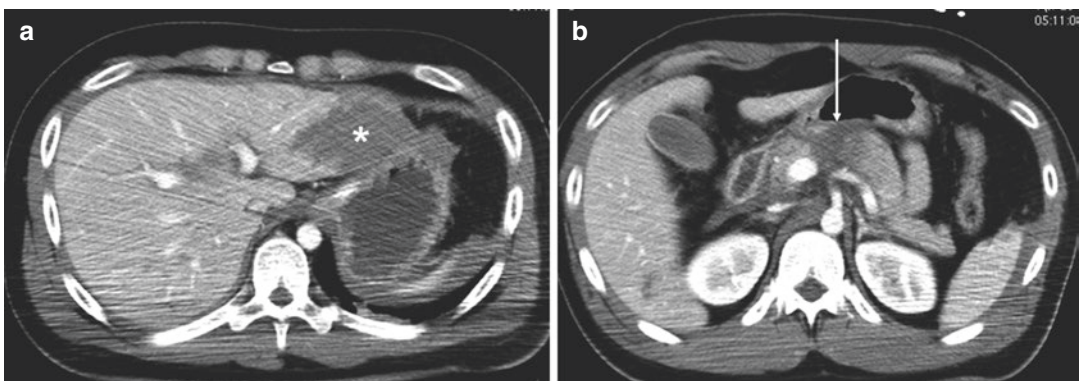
Pancreatic body transection. Axial CT scan (a, b) and coronal reconstruction (c) show the transection as a thick hypodense linear image through the pancreatic body (*arrow*). A traumatic injury of the hepatic left lobe is
